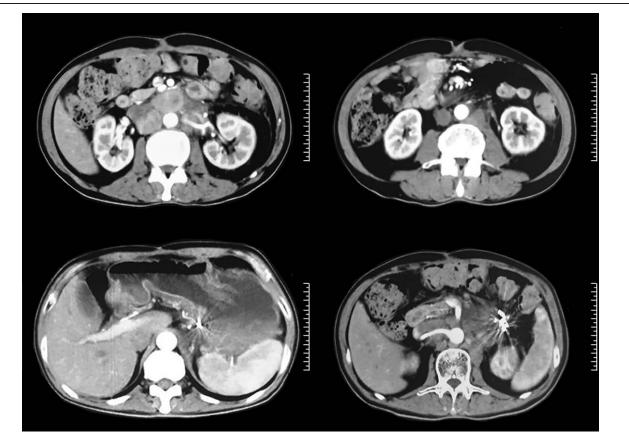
Two-month postolaparib treatment (October 20, 2017), CT suggested the overall efficacy of target therapy, which was evaluated for partial response.
